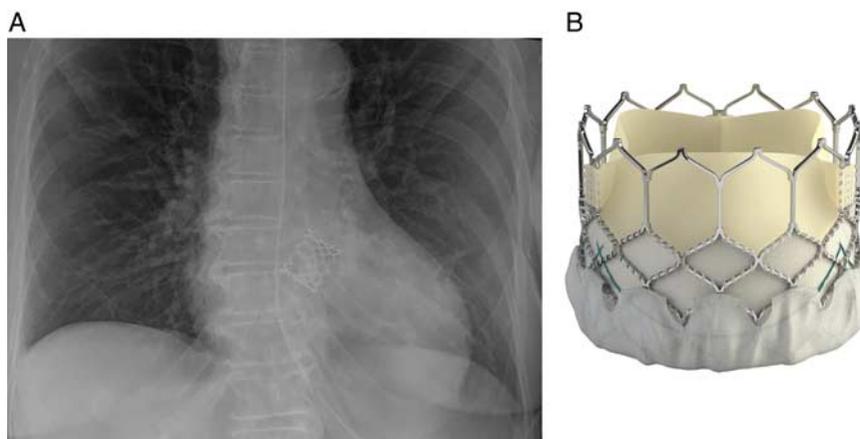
Edwards Sapien 3 after transcatheter aortic valve replacement: frontal (A) radiograph after Edwards Sapien 3. Note the different stent cell sizes, which allow for more accurate positioning, because of variable foreshortening of the valve during expansion. Sapien 3 (used with permission) (B). [full color online](#)
